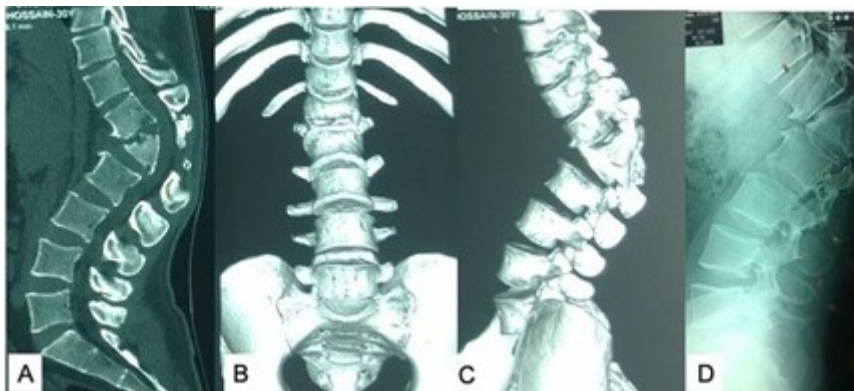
(A) Sagittal view; (B,C) three-dimensional reconstruction of CT scan of lumbodorsal spine and (D) X-ray lumbodorsal spine lateral view showing congenital kyphosis due to anomalous L1 vertebra. Source: Figure by authors.
